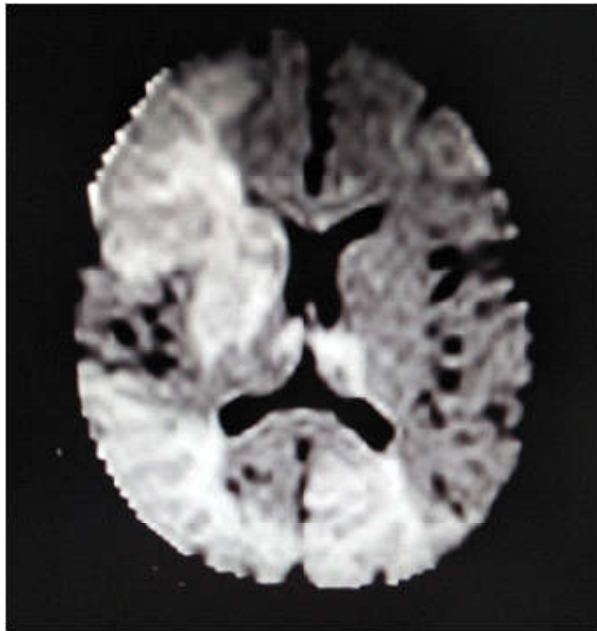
MRI Brain showing right MCA, ACA, PCA and left ACA, part of ACA and PCA infarction.
